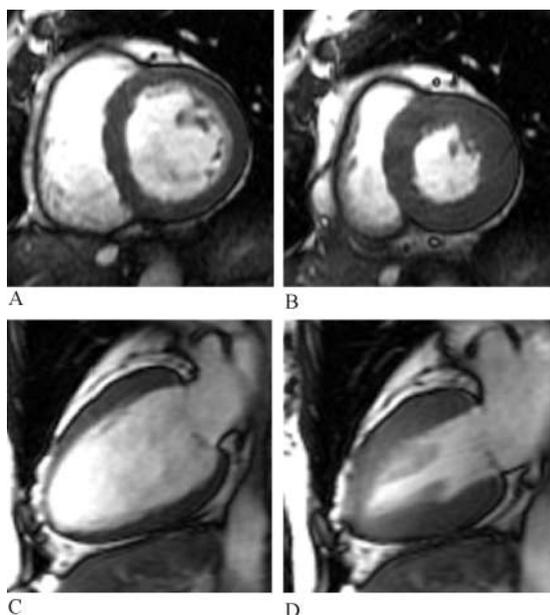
Breath-hold cine MR images of the left ventricle acquired with SSFP sequence in a patient with angina pectoris. A, Short-axis image at end-diastole; B, short-axis image at end-systole; C, long-axis image at end-diastole; D, long-axis image at end-systole. Excellent contrast is observed between the blood pool and the myocardium throughout the cardiac cycle.
